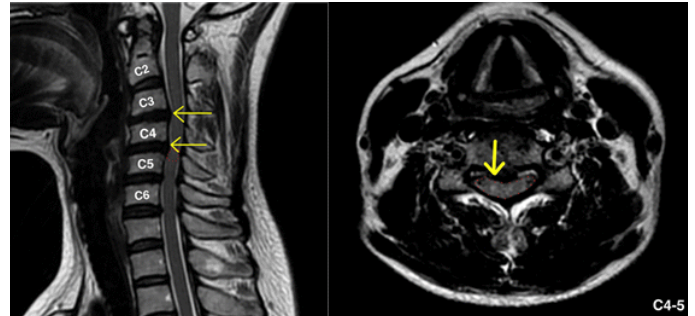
C-spine MRI of Case 1.
